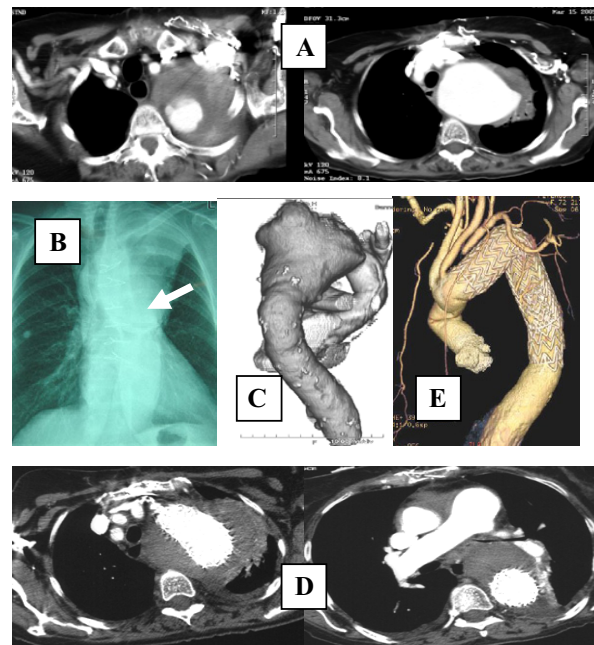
Images of a female patient presented with three episodes of hemoptysis and the bronchoscopic finding of a left aorto-bronchial fistulae. Three months earlier underwent an ascending aortic repair (TAA) with an interposition graft. A, Preoperative CT-scan view of the proximal 3rd of the DTA causing an AoBF. B, CXR demonstrating a compression of the left main bronchus (white arrow). C, Preop 3-D CT reconstruction and the proximal aneurismal mass. D, Postoperative CT-scan views confirming the adequate exclusion of the aneurysm. The arrow highlights the proximity of the aneurysm to the bronchus. E, 3-D CT reconstruction 18 months after the treatment. The mass virtually resolved.
